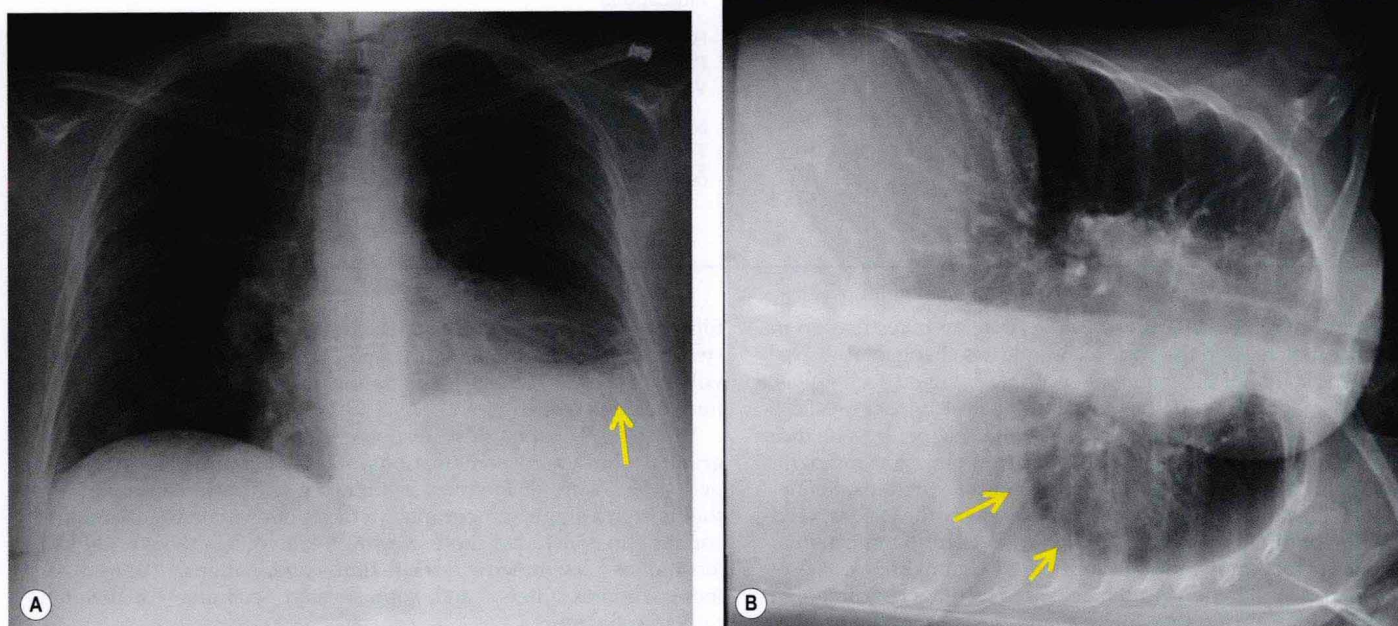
Lateral decubitus view. A, Erect frontal chest radiograph shows blunting of the left costophrenic angle (arrow), potentially caused by pleural effusion. B, Lateral decubitus view confirms pleural effusion by showing that some of the pleural fluid gravitates along the left lateral chest wall (arrows).
